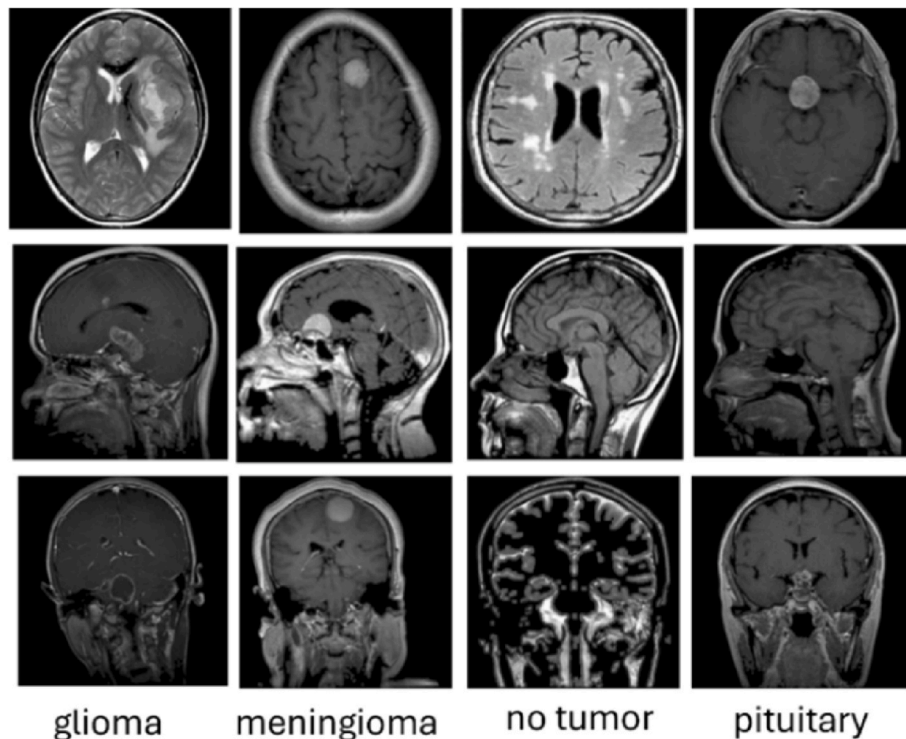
Examples of brain MRI images include Glioma, Meningioma, No Tumour, and Pituitary.
